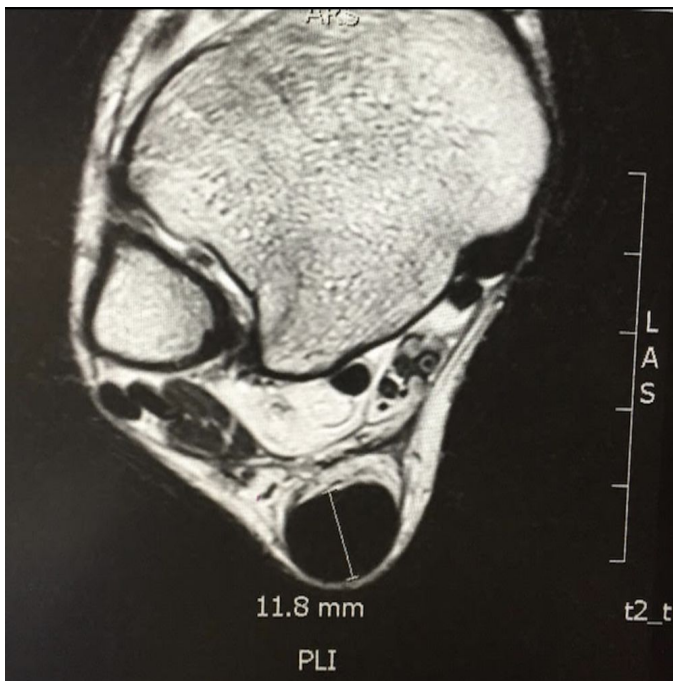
Axial view MRI showing Achilles tendon thickness of 11.8mm.
